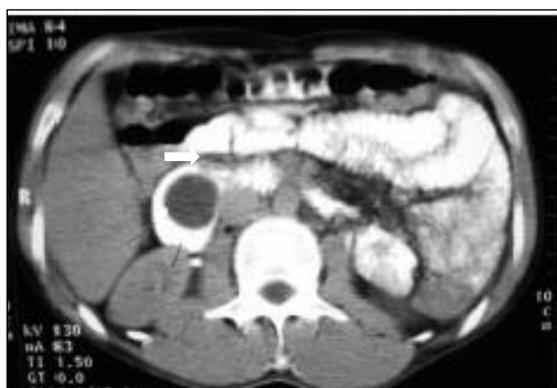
Intravenous contrast enhanced abdominal CT imaging : formation hanging from the inner wall of D2
